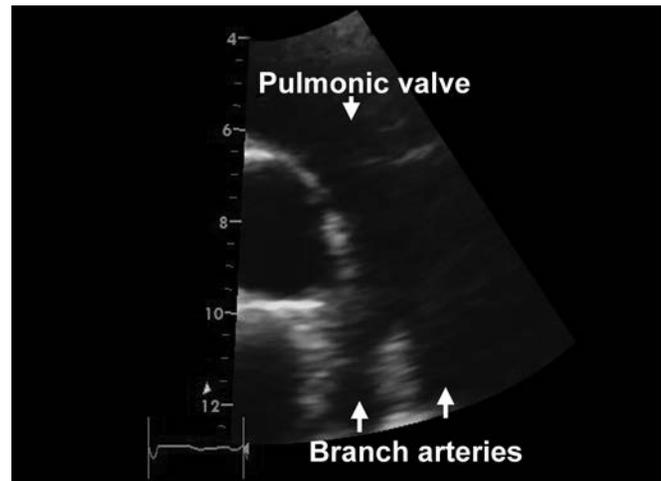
Postoperative transthoracic echocardiogram of the pulmonary artery bifurcation.
